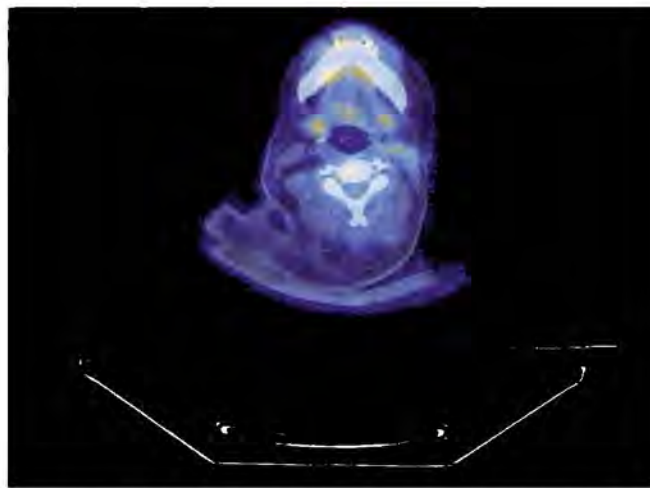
Three months later, the patient has completed eight cycles of chemotherapy and is reimaged by positron emission tomography/computed tomography (PET/CT). Continued improvement of hypermetabolism is seen within the residual mass, consistent with favorable response to therapy. Additional serial imaging was subsequently obtained that followed the patient to complete remission after completion of chemotherapy.
